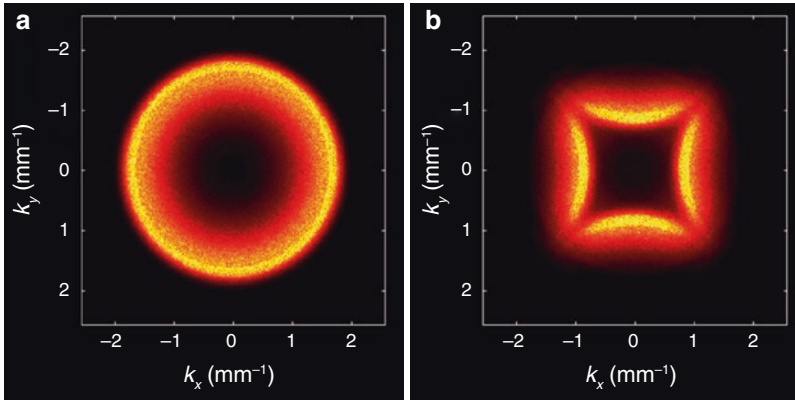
2D CT NPS of a cylindrical and uniform object placed at the isocenter of a diagnostic MDCT system (GE Discovery CT750 HD). A high-definition edge-enhancing reconstruction kernel (HD Edge) provided by the system was selected for image reconstruction. NPS in (a) was measured using images with a reconstruction pixel size
